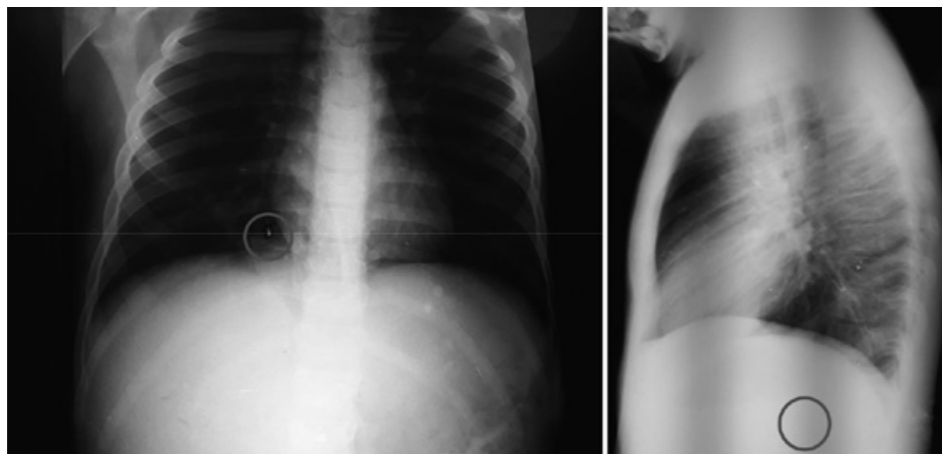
Chest X-ray showing the FB in the right lower lobe (AP and Lateral view)
